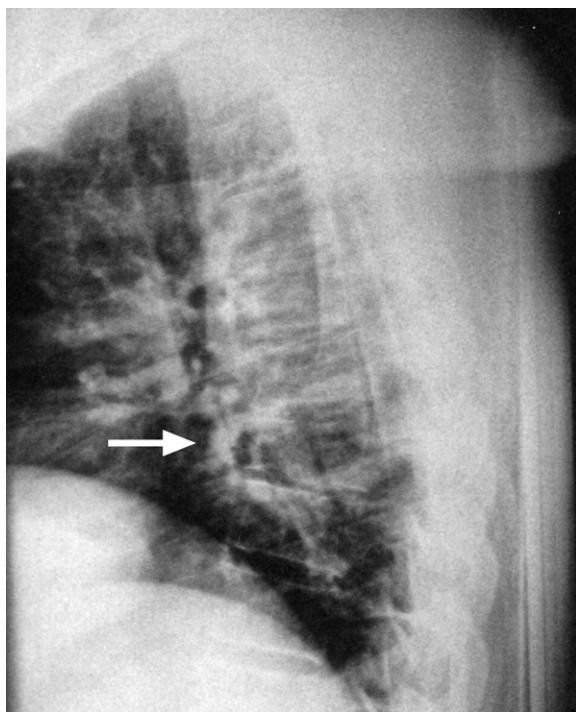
Thoracic spine lateral plain X-ray image. Reported as '...no wedge fractures demonstrated'. However, note the compression fracture at approximately the T7 vertebral body level (arrow).
